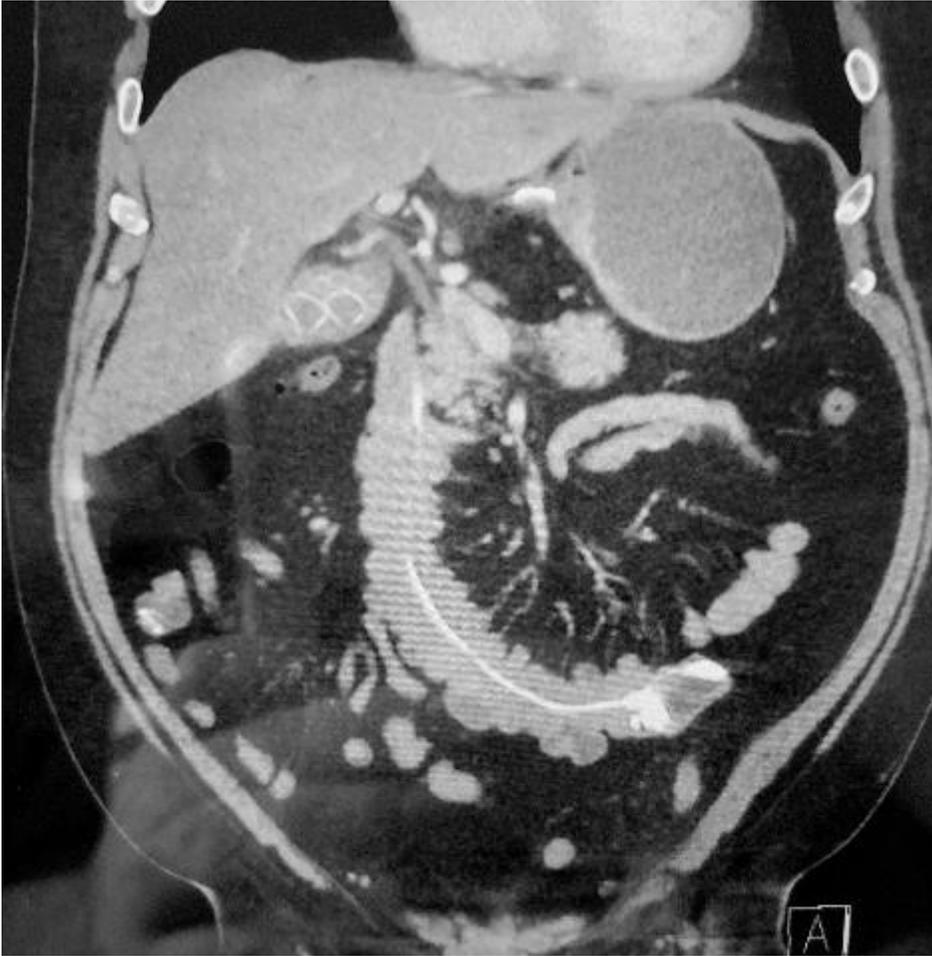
CT scan of the abdomen. Evidence of laparoscopic gastric band that has eroded into the stomach and is not present distally in the small bowel.
